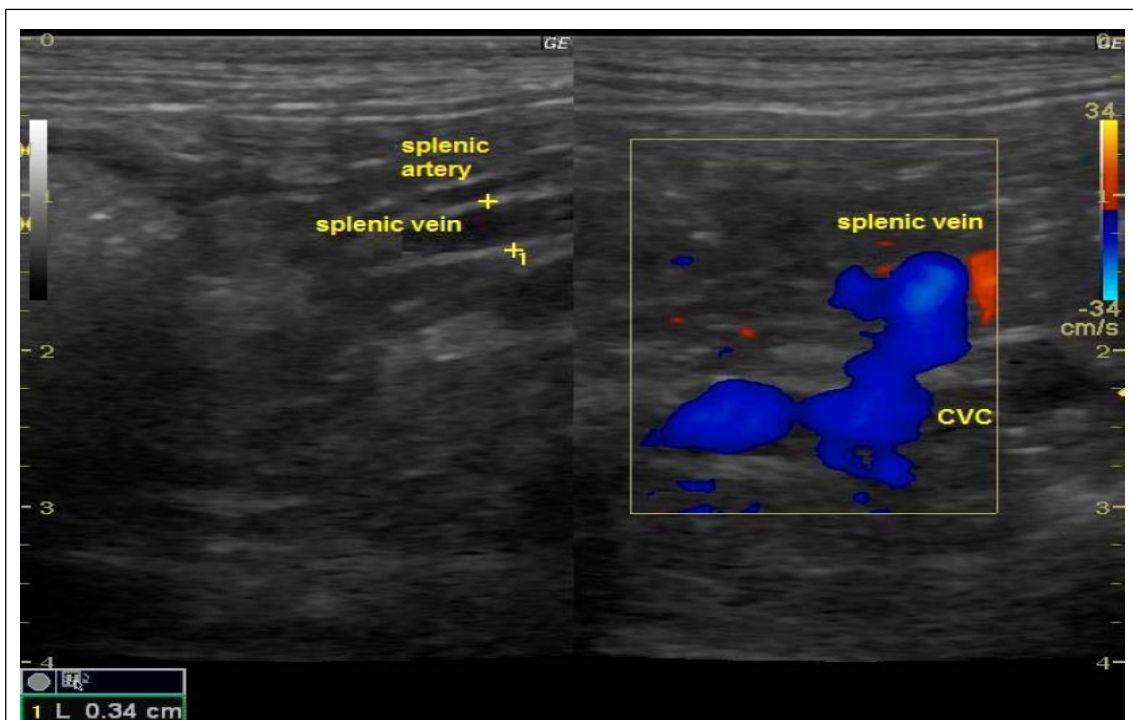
Color Doppler ultrasonography showing shunting vessel between splenic vein and caudal vena cava.
